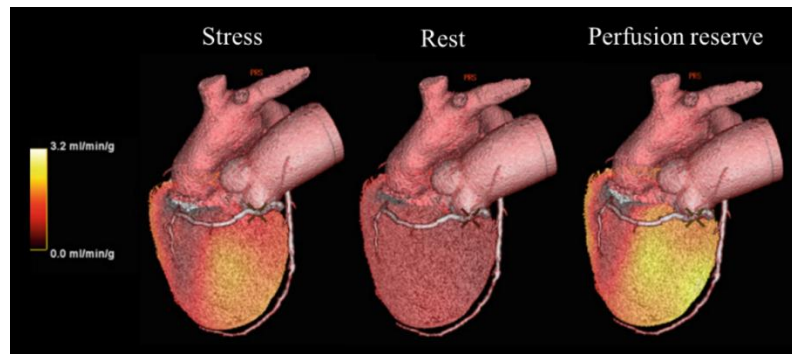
Fused 3D views of quantitative $^{13}\text{NH}_3$ PET data (stress, rest, and perfusion reserve) and coronary artery anatomy obtained with CT. The stress-induced regional reduction in hyperemic flows is observable in the territory of right coronary artery while no significant MBF reduction is seen at rest. Adapted from [Marinelli 2013].
